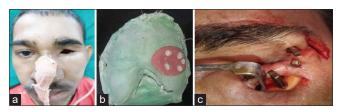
(a) Preoperative view, (b) radiographic template fabricated on the diagnostic cast with self-cure acrylic and radiopaque markers, (c) three 3.6\*8 mm single-piece implants with customized abutment length of 12 mm
